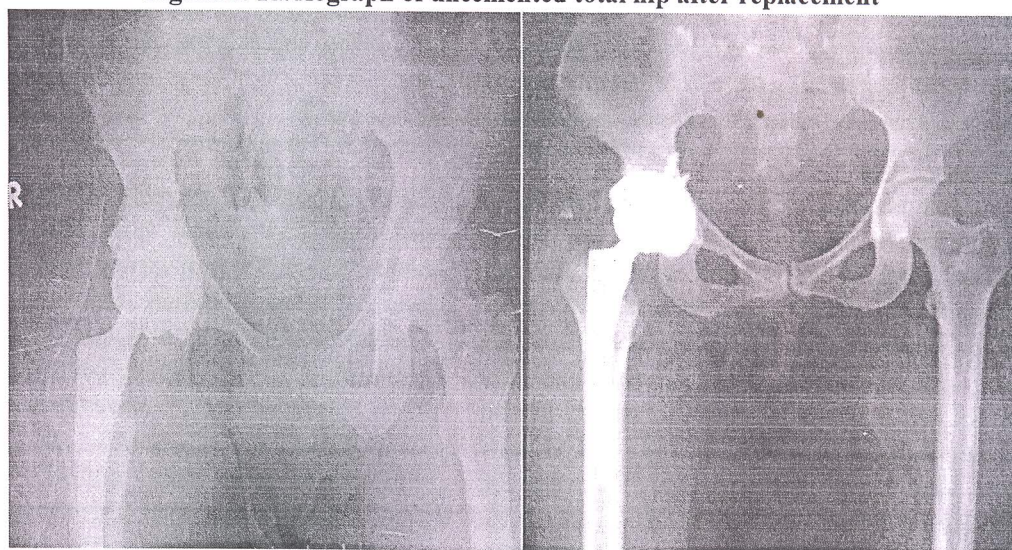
Radiograph of uncemented total hip after replacement
